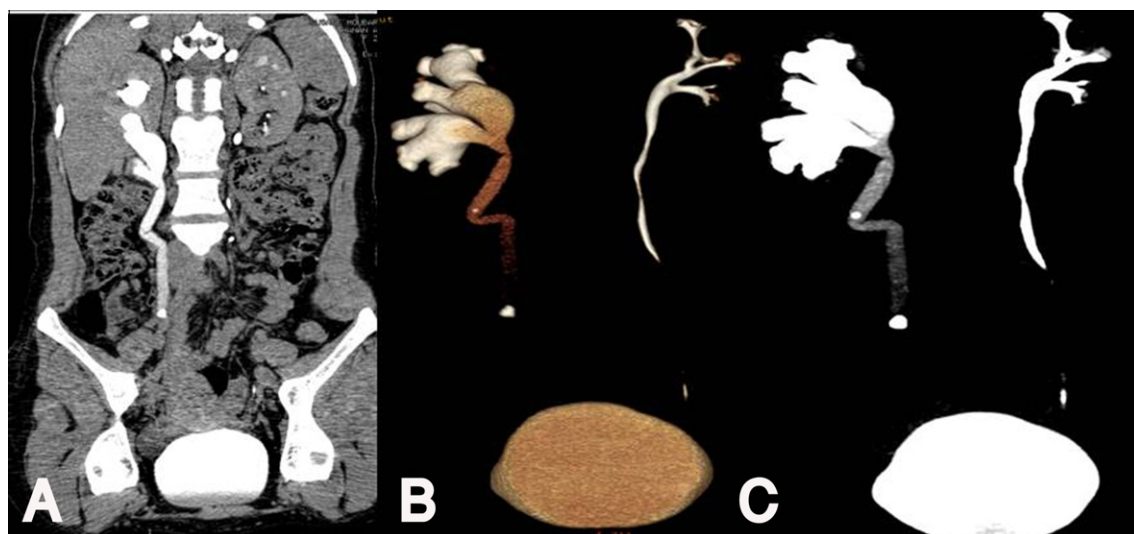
Fifty-four year old patient with right hydronephrosis. Coronal CPR image (A), coronal VR (B) and its corresponding MIP (C) images in excretory phase of CT urography show clearly the cause and level of obstruction (a stone at the middle third of the right ureter). Normal left kidney and ureter. A non obstructing stone seen at the upper third right ureter.
